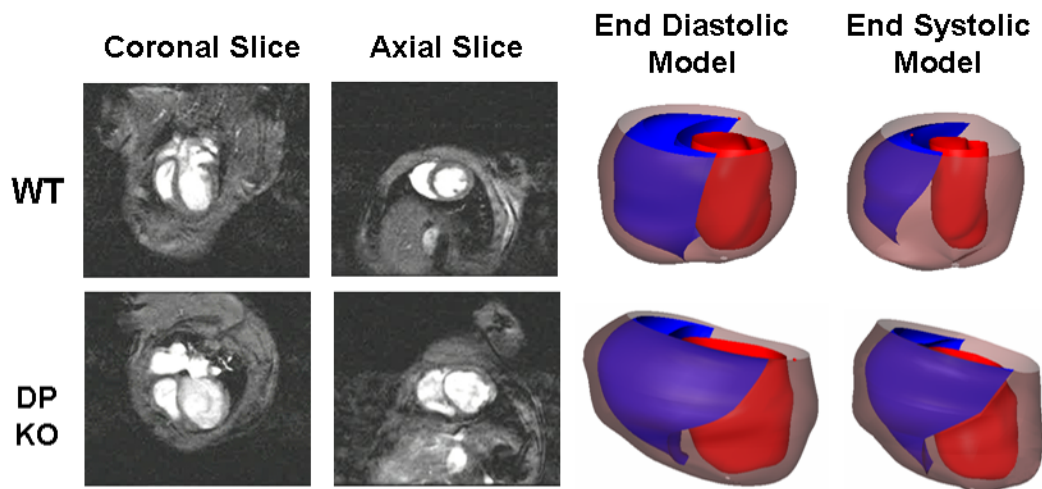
MRI and 3D models of DPKO and WT hearts.
